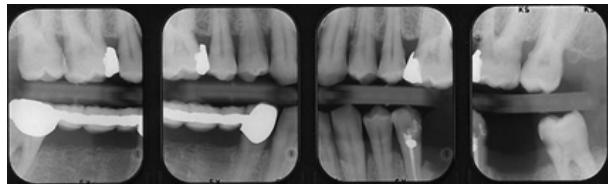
Vertical Bitewing Survey
